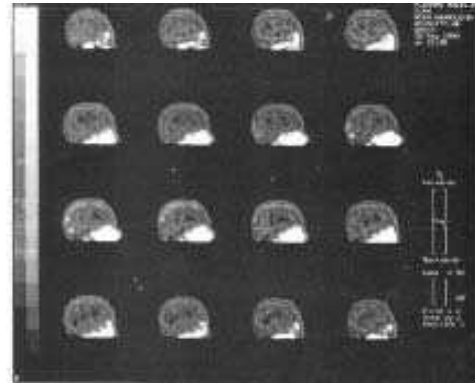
Patient no. (12): SPECT scanning showed perfusion defects in both frontal, left parietal and left occipital cortex, hypo perfusion of cerebellum and deep subcortical structures (sagittal view).
